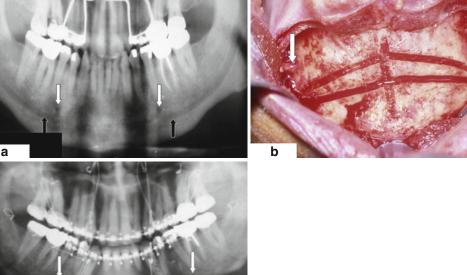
Relationship of mental foramen (MFN) to inferior alveolar canal (IAC): (a) preoperative x-ray shows MFNs (*white arrows*) are several millimeters superior to IACs (*black arrows*); (b) osseous markings made for osteotomies for reduction of chin height and chin advancement are located inferior to mental nerves (*white arrows*);
